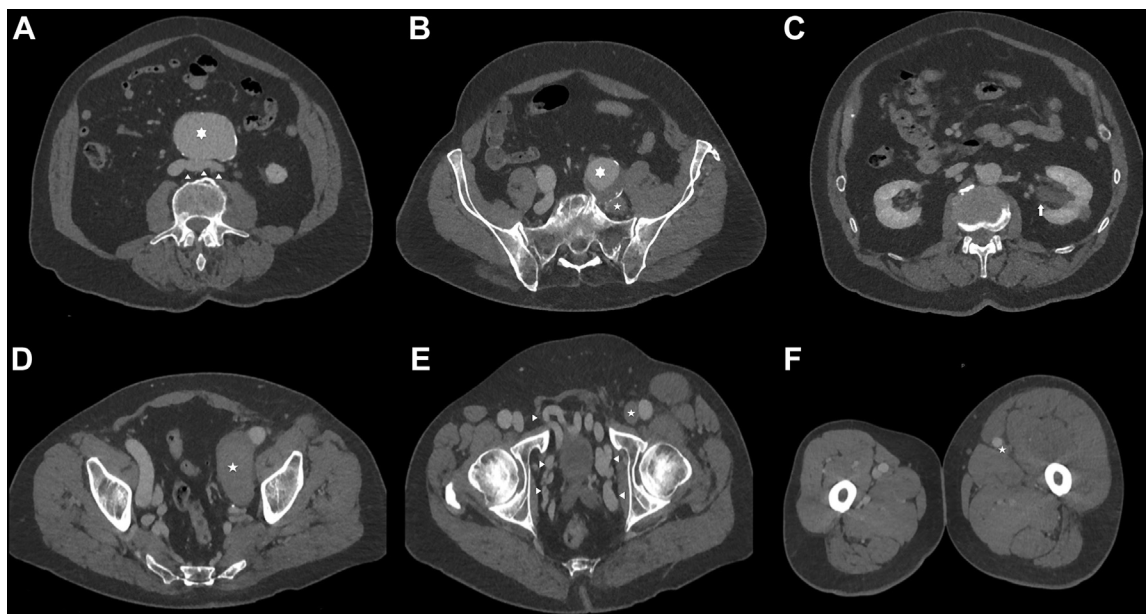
Axial contrast-enhanced computed tomography (CT) scans the in venous phase from the level of the kidneys to the proximal thigh. A, Abdominal aortic aneurysm (*), left renal vein (*arrowheads*). B, Aneurysm of the left common iliac artery (large *) and thrombosed common iliac vein (small *). C, Left hydronephrosis (*arrow*). D, Aneurysmatic and thrombosed left external iliac vein (*). E, Thrombosed left common femoral vein (*) and collateral pelvic veins (*arrowheads*). F, Thrombosed left superficial femoral vein (*) and a significant edema.
